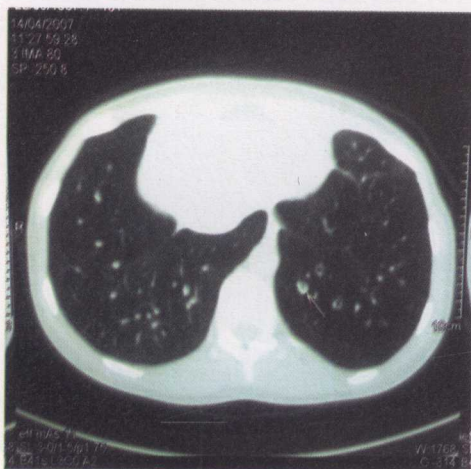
Spiral chest CT in a 23-year-old female patient suffering from left lower lobe bronchiectasis.
